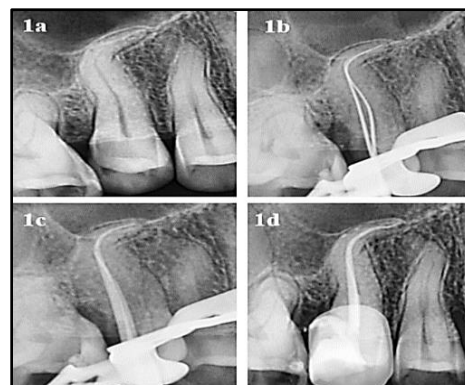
(a) Pre-Operative radiograph (b) Working length (c) Master cone (d) Obturation
